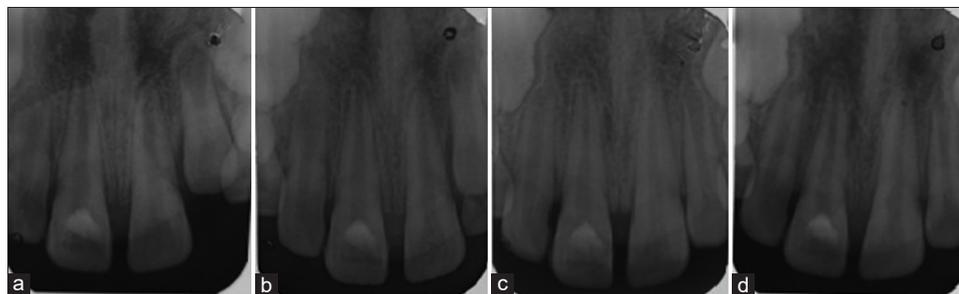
Radiographic image of the fractured permanent maxillary 11 after (a) 1-month follow-up (b) 3-month follow-up (c) 6-month follow-up (d) 12-month follow-up.
